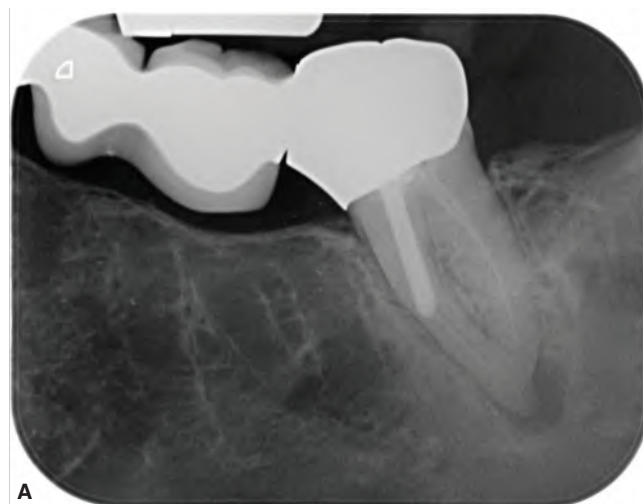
A. Marked ledging with potential perforation in the mesial resulted in an inadequate post placement; B. Following removal of the bridge and the post the ledge was sealed using MTA and access to the original root canal was regained; C. Post-obturation radiograph.
